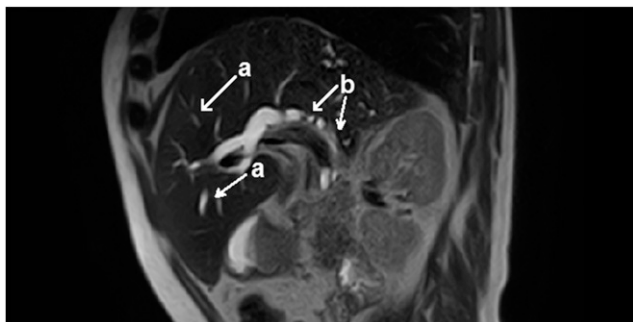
Case 1. Magnetic resonance imaging: signs of cholangiocarcinoma (axial view). (A) Enlarged intrahepatic bile ducts; (B) the common bile duct is not distinctly differentiated within 1.0 cm; its diameter is enlarged up to 1.0 cm in the proximal and middle part.
